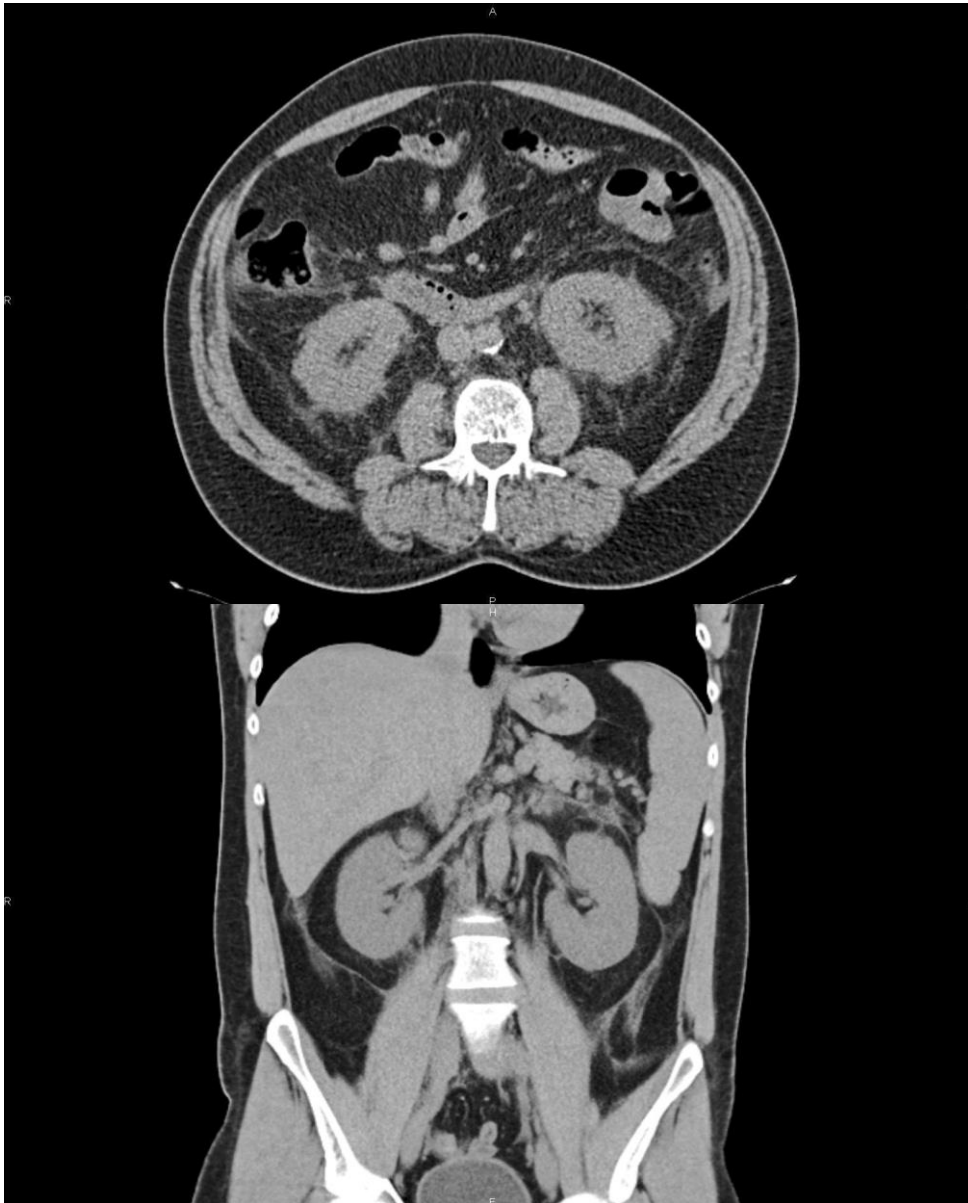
Unenhanced abdominal CT, axial (a) and coronal (b) sections (different patients). Axial image (a) shows stranding of the perinephric fat as well as outside the perirenal fascia. Coronal image (b) shows similar findings, with splenomegaly (15.7 cm).
